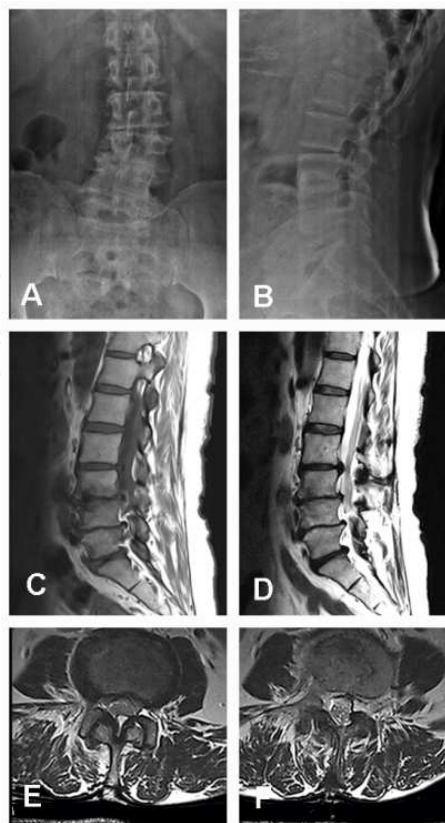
A. Antero-posterior radiograph with left lumbar scoliosis, plastic deformation of the last three lumbar vertebrae, vertebral platform sclerosis, osteophytes, and decreased height of intervertebral spaces. B. Lateral radiograph of lumbar spine with spinal platform sclerosis, osteophytes, and reduced height of the L3–L4, L4–L5, and L5–S1 IDs. C. Sagittal MRI of lumbar spine in T1 phase with sclerosis of the vertebral platforms, Modic changes, osteophytes, decreased height of IDs, and disc protrusion at L3–L4, L4–L5, and L5–S1 with narrow lumbar canal. D. Sagittal MRI of lumbar spine in T2 phase with vertebral platform sclerosis; osteophytes; decreased height of IDs; disc protrusion at L3–L4, L4–L5, and L5–S1 with lumbar canal narrowing; decreased spaces at L3–L4 and L4–L5; and bulging of IDs at L2–L3 and L5–S1. E–F. MRI axial slices of lumbar spine facet degenerative changes and hypertrophy of the ligamentum flavum and lumbar stenosis at different levels.
